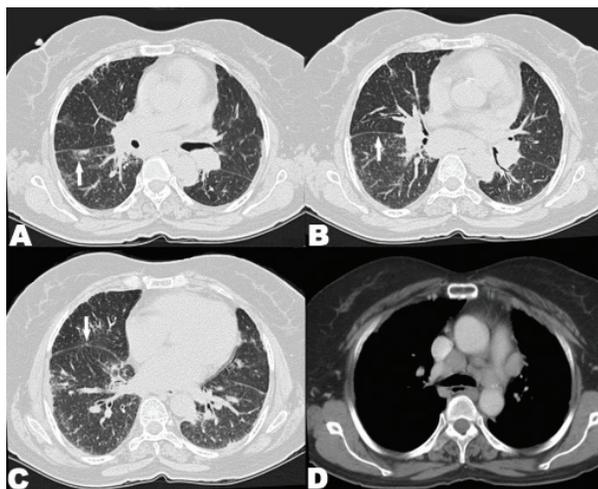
Known patient of sarcoidosis. Axial CT sections lung window (A,B,C) showing perilymphatic nodules (white arrows) along the fissure, pulmonary fibrosis, thickening of peribronchovascular interstitium. Axial CT section mediastinal window (D) showing right paratracheal lymphadenopathy
